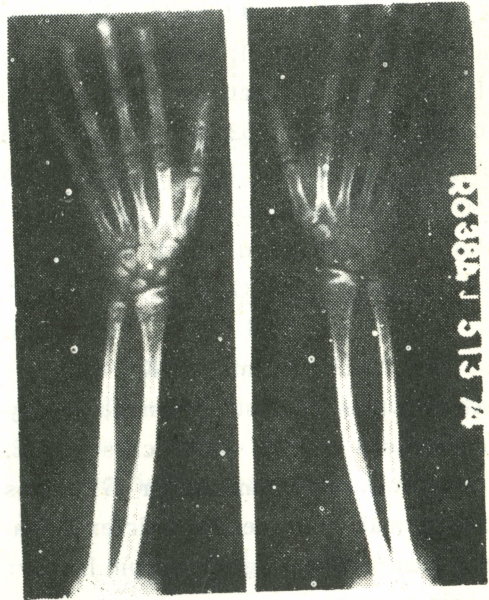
X-ray examination of both hands showed slender fingers.
